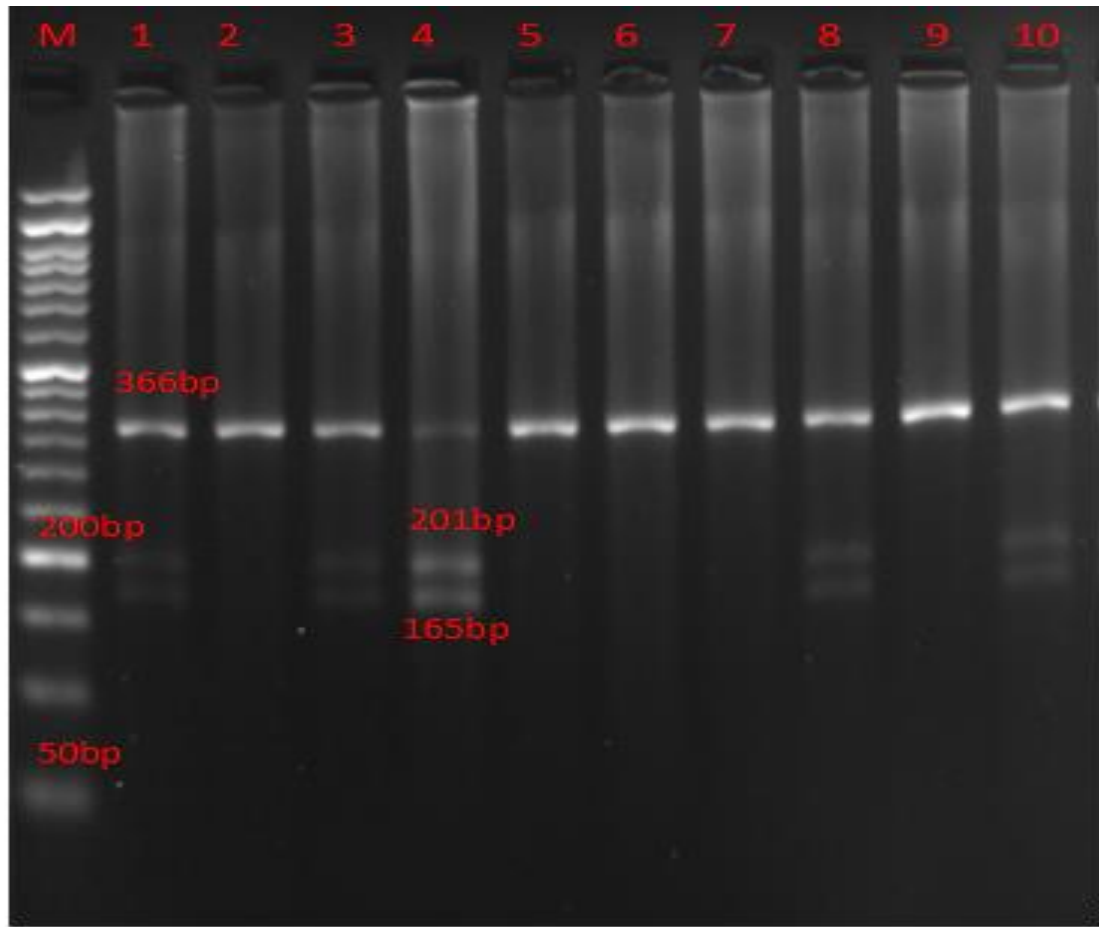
PCR RFLP analysis c.742C>T polymorphism in the of AHSB. Lane M: 50 bp marker: Lanes 1,3,8,10: CT alleles ;Lanes 2,5,6,7,9: CC alleles ; Lanes 4:TT alleles
